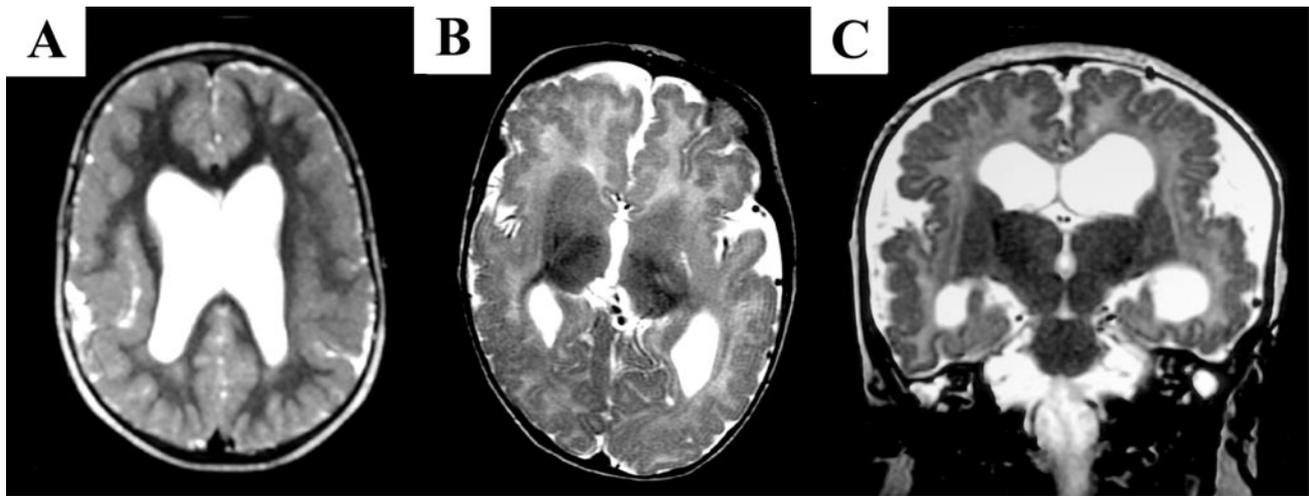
Representative T2-weighted MRI from patients with bilateral generalized polymicrogyria. (A) Axial image from Patient 7 at 2 years of age. (B) Axial image from Patient 5 at 4 months of age. The high gray–white contrast of these two T2-weighted images highlights the polymicrogyric folding of the cortex. Enlarged ventricles are also present. (C) Coronal image from Patient 1 at 4 months of age. In addition to generalized polymicrogyria, this image also demonstrates abnormally rotated hippocampi, enlarged ventricles, and enlarged extra-axial CSF spaces.
